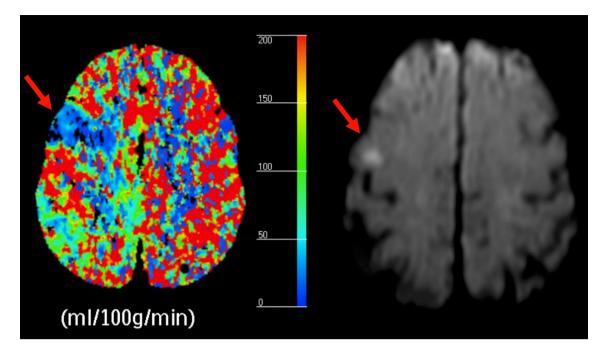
Acute cerebral blood flow map (left) showing an hypoperfused area (arrow) in the superficial territory of the right middle cerebral artery, where 2 days later MRI with diffusion-weighted imaging (right) demonstrated an acute ischemic lesion
